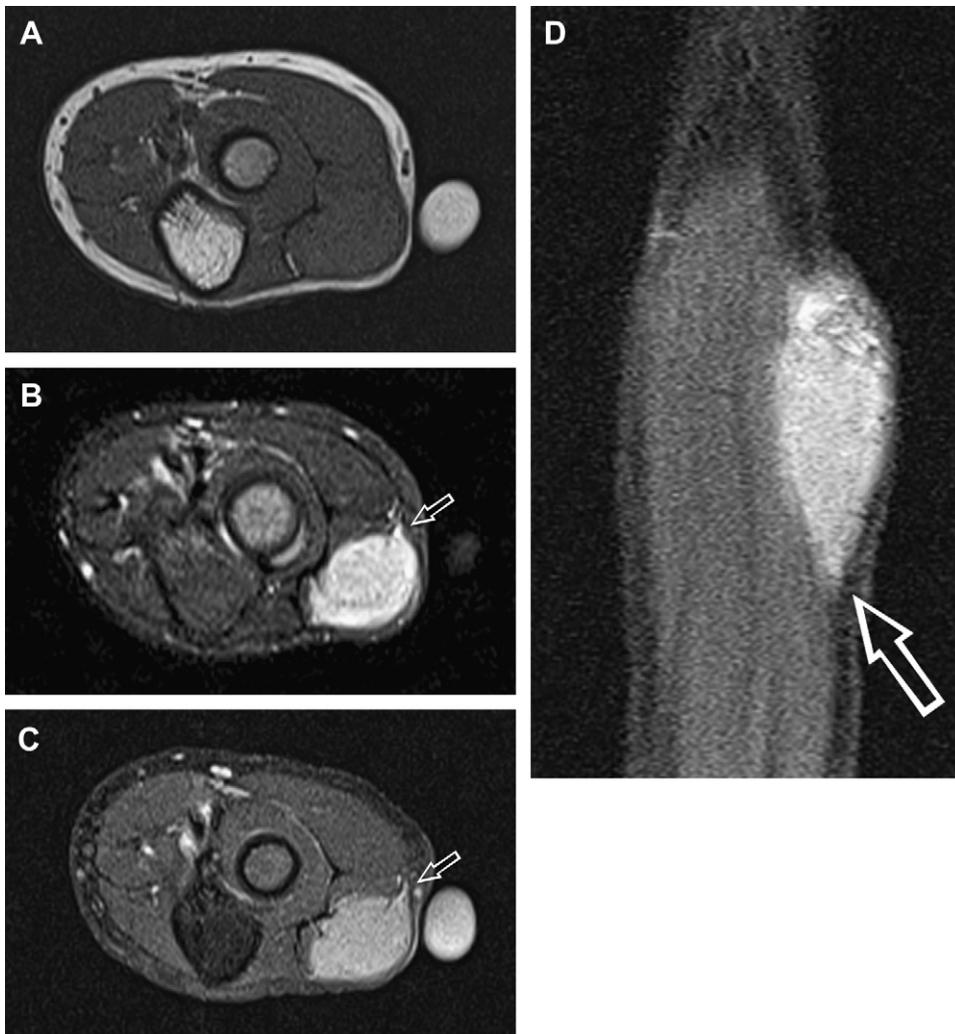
Nodular fasciitis. Nodular fasciitis in a 5-year-old boy who presented with a palpable elbow mass. (A) Axial T1W (repetition time/echo time [TR/TE], 501/15) MR image demonstrates a subcutaneous soft tissue mass, which is isointense to mildly hyperintense compared with muscle. This mass is hyperintense on (B) axial short tau inversion recovery (STIR) image (TR/TE, 4700/35). Axial (C) and sagittal (D) T1W, postcontrast, fat-suppressed (TR/TE, 704/15) MR images reveal relatively homogenous diffuse enhancement. Mild linear fascial extension (fascial tail sign, *white arrows*) is demonstrated on STIR and postcontrast imaging.
